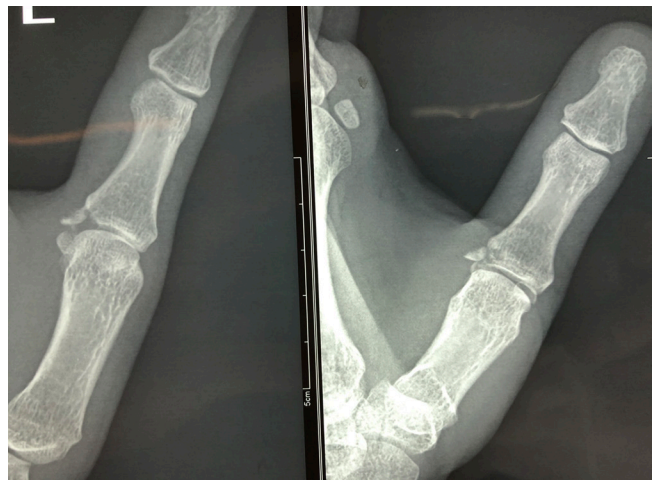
Plain radiography of the left thumb demonstrates the UCL fracture-avulsion lesion.
